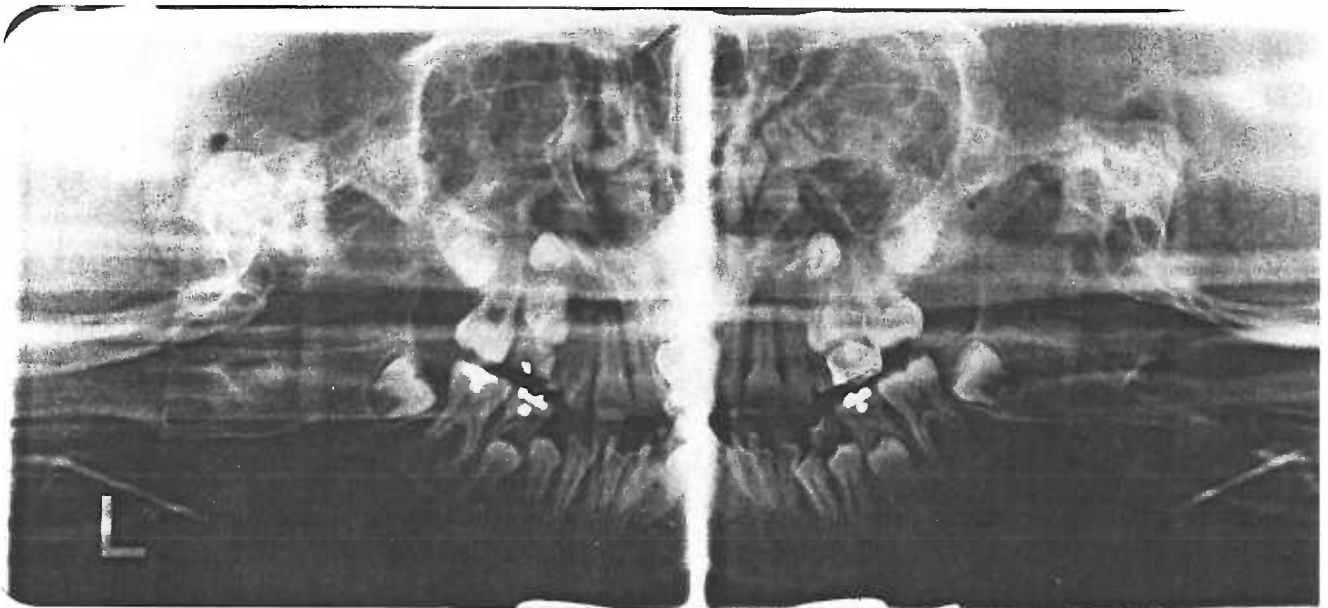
Panoramic radiograph showing the severe crowding. The small follicles appearing in the upper premolar regions are the cuspids.
